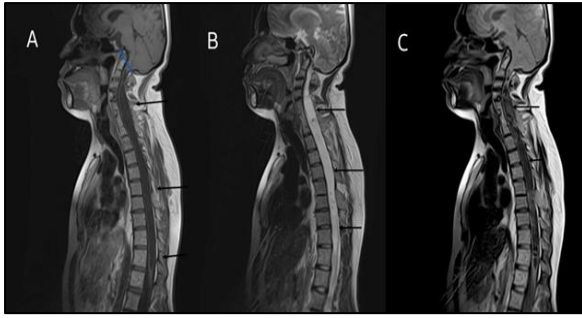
MRI cervical spine (sagittal sections): (A) T1W (B) T2W and (C) Flair sequence.
